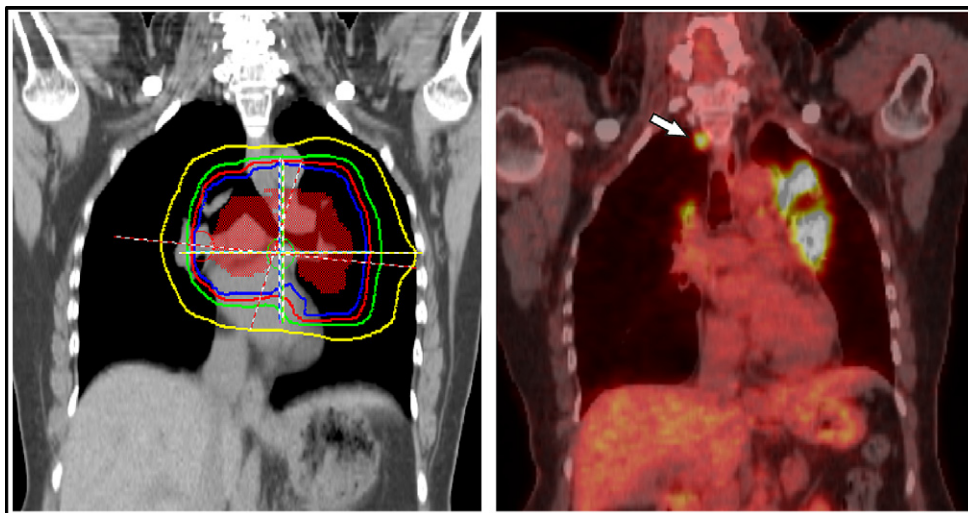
Example of isolated elective nodal failure in our cohort. (Right) Intensity-modulated radiotherapy planning dose volumes for this patient, who received 45 Gy in 30 fractions given twice daily (orange, clinical target volume; blue, 45 Gy isodose line; red, 36 Gy; green, 20 Gy; yellow, 5 Gy). (Left) Elective nodal failure in right paratracheal lymph node (white arrow) observed on surveillance positron emission tomography/computed tomography scan obtained about 3 months after radiotherapy completion. Other areas of ^{18}F -fluorodeoxyglucose avidity on the image indicate inflammation and did not appear on subsequent scans.
